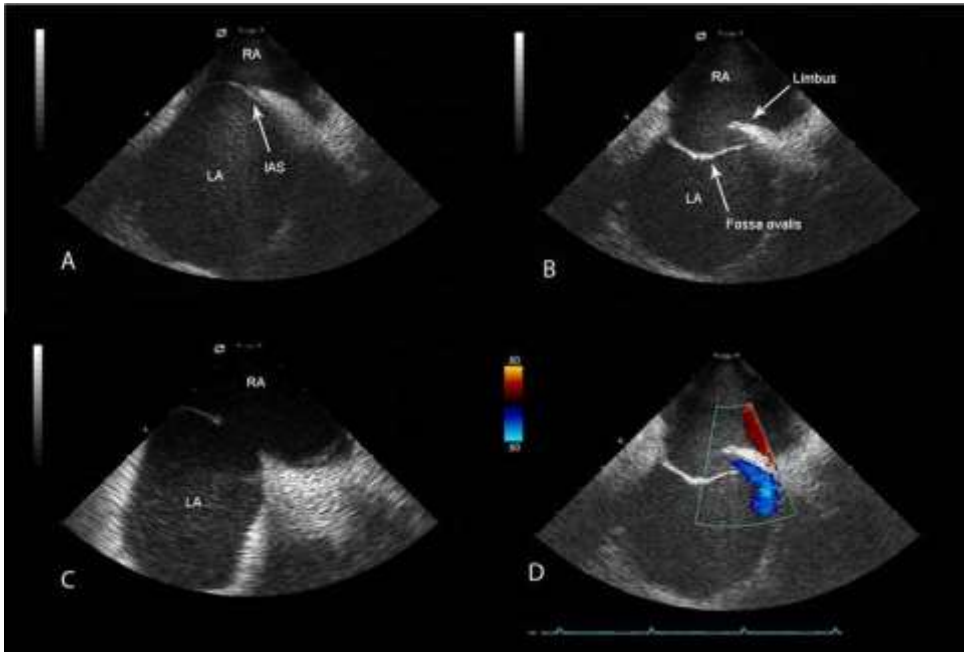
Panel A: Interatrial septum (IAS), left atrium (LA) and right atrium (RA). Panel B: During a Valsalva maneuver the patent foramen ovale (PFO) is revealed. Panel C: A large type II atrial septal defect (delineated by the two markers). Panel D: Doppler flow delineates the flow across PFO during a Valsalva maneuver.
